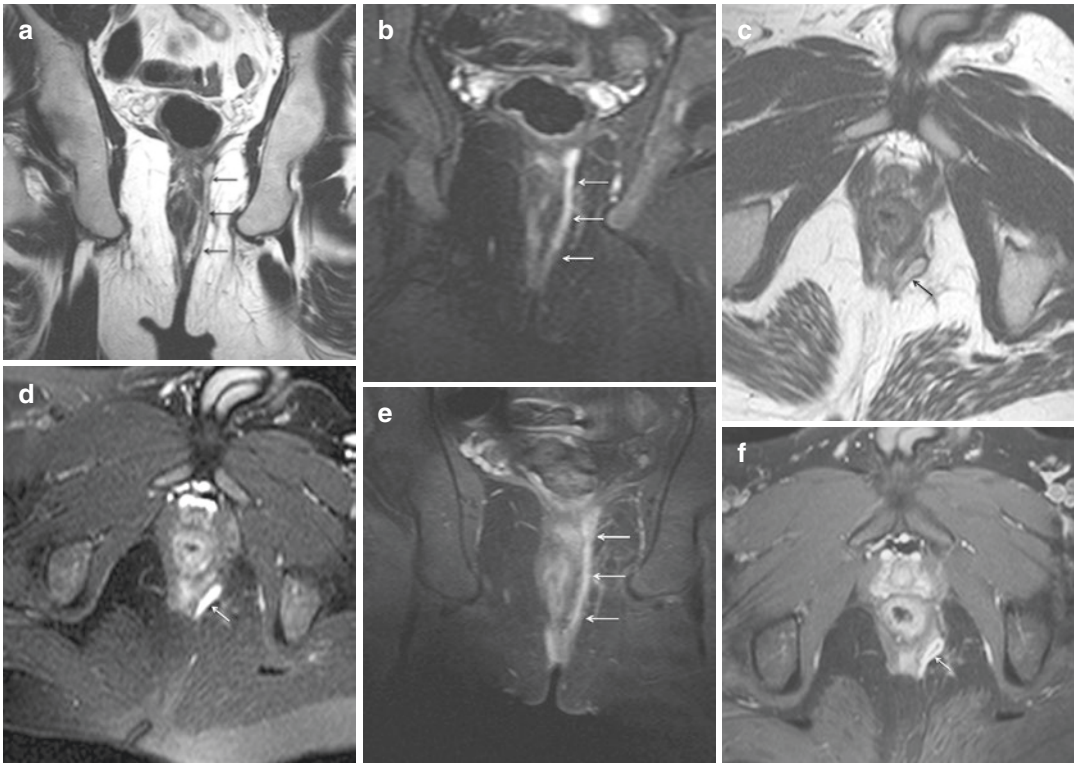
Extra-sphincteric fistula. Coronal-oblique (a, b) and axial-oblique (c, d) T2-weighted TSE images, performed without (a, c) and with fat saturation (b, d) show a left hyperintense extra-sphincteric fistula (arrows). On
